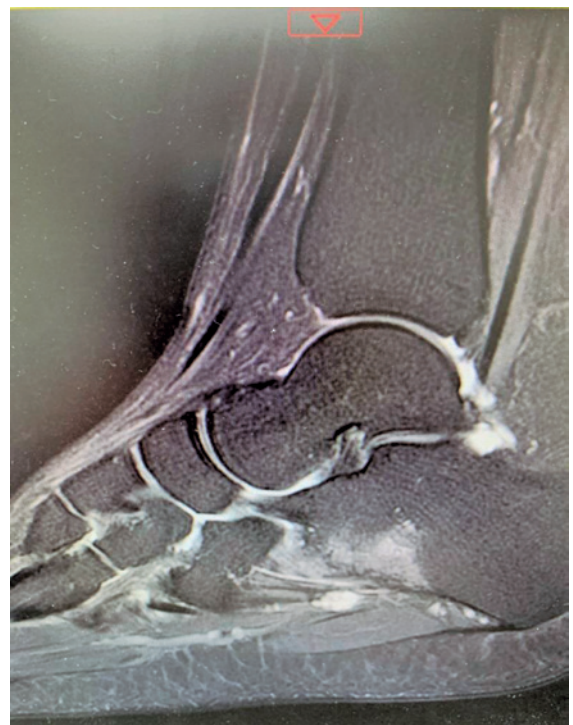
T2-weighted sagittal MRI scan performed in 2017, which showed a hypersignal plantar lesion within the soft tissue causing adjacent bone edema in the calcaneus.
